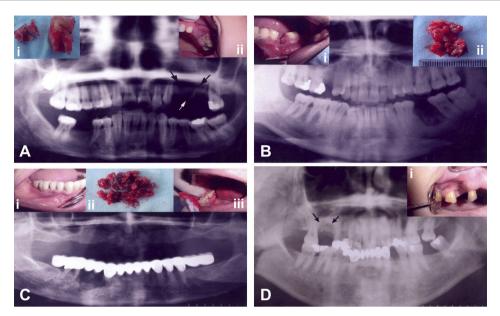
(A) Preoperative panoramic radiograph showing an extensive radiolucent lesion in the left maxillary premolar region (arrows). (i) Excised sequester and extracted neighboring molar tooth. (ii) Clinical view showing sequester and erythema of the gingiva in the maxillary premolar region. (B) Preoperative panoramic radiograph with radiolucent and sclerotic areas of the lesion in the left mandibular molar region. (i) Clinical view of an unhealed alveolar socket. (ii) Excisional biopsy material consisting of soft tissue and sequester. (C) Preoperative panoramic view showing radiolucent and radiopaque areas in the right mandibular premolar region below the prosthetic restoration. (i and iii) Preoperative clinical views showing gingival erythema and swelling of the right mandibular premolar region. (ii) Biopsy material. (D) Preoperative panoramic X-ray showing the right maxillary molar area with osteolytic and sclerotic lesion (arrows). (i) Clinical view of unhealed tooth socket and gingival erythema.
